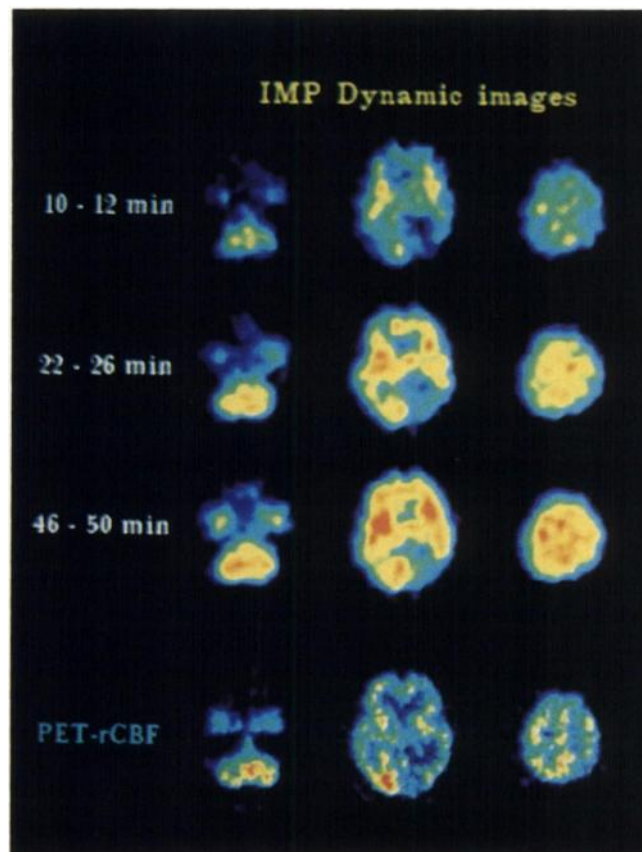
Corresponding IMP-SPECT and PET images in a patient with CVD (P7 in Table 1). The dynamic IMP images were measured from 10-12 min, 22-26 min and 46-50 min after intravenous injection of IMP. The PET-rCBF images were calculated using an $H_2^{15}O$ autoradiographic method. Selected slices were OM+7.0, +42.0, and +77.0 mm in SPECT, and OM+7.0, +39.5 and +78.5 mm in PET.
